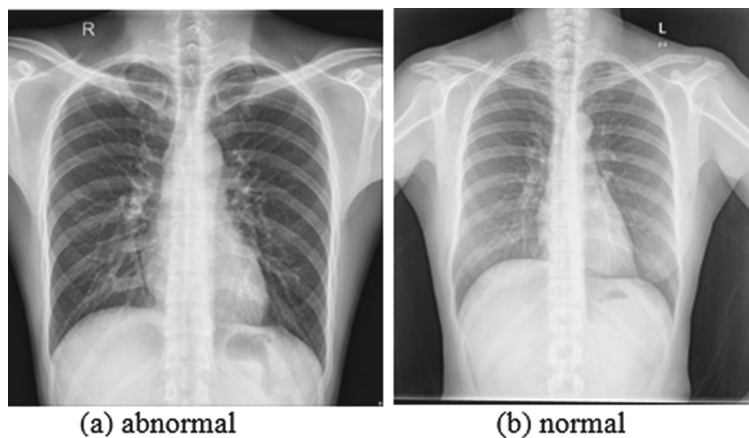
Sample of the normal and abnormal chest X-rays.
